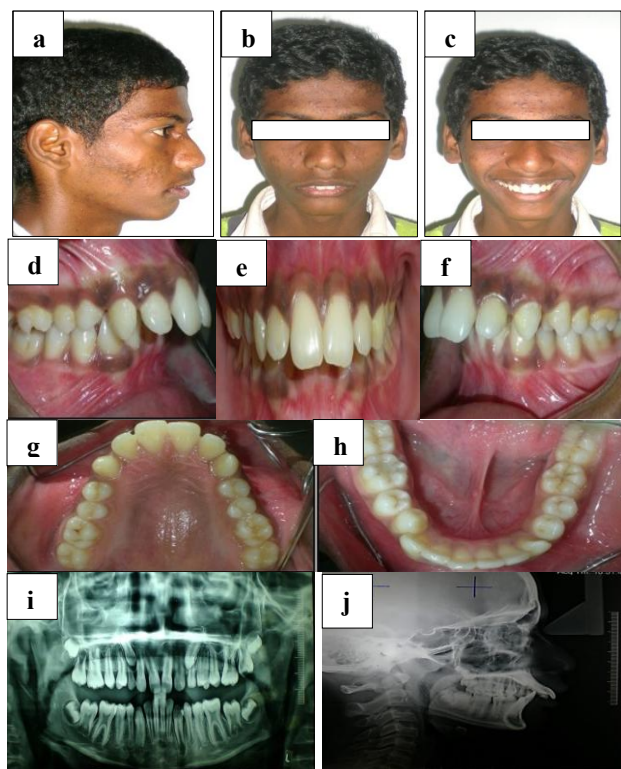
(a-j): Pre-treatment documentation including extraoral and intraoral clinical photographs, panoramic radiograph (orthopantomogram), and lateral cephalogram.
